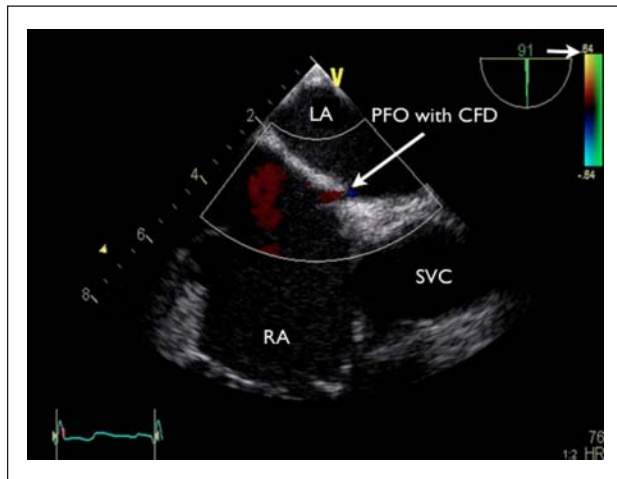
Transesophageal echocardiography mid-esophageal bicaval view demonstrating a patent foramen ovale (PFO) with color flow Doppler (CFD)
